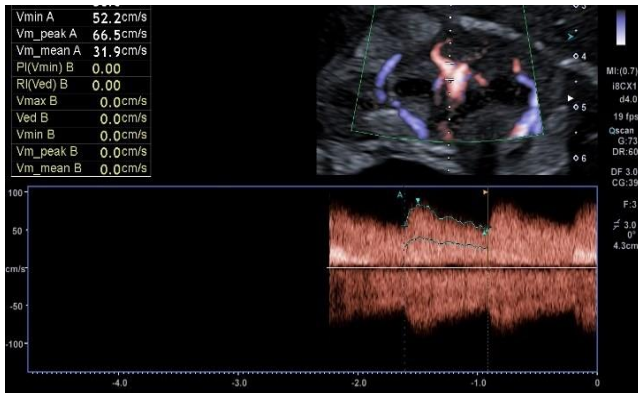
Doppler-Ultrasound revealing arteriovenous fistula of 6mm on the medial-third of right kidney. The image depicts increasing vascularization and an arteriovenous flows characterized by low resistance.
